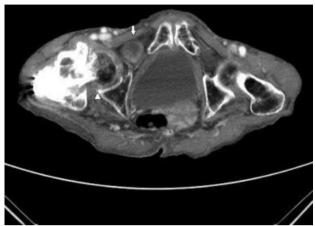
CT pelvis demonstrating a small bowel loop descending into the right obturator canal anterior to the obturator externs muscle (white arrow).
